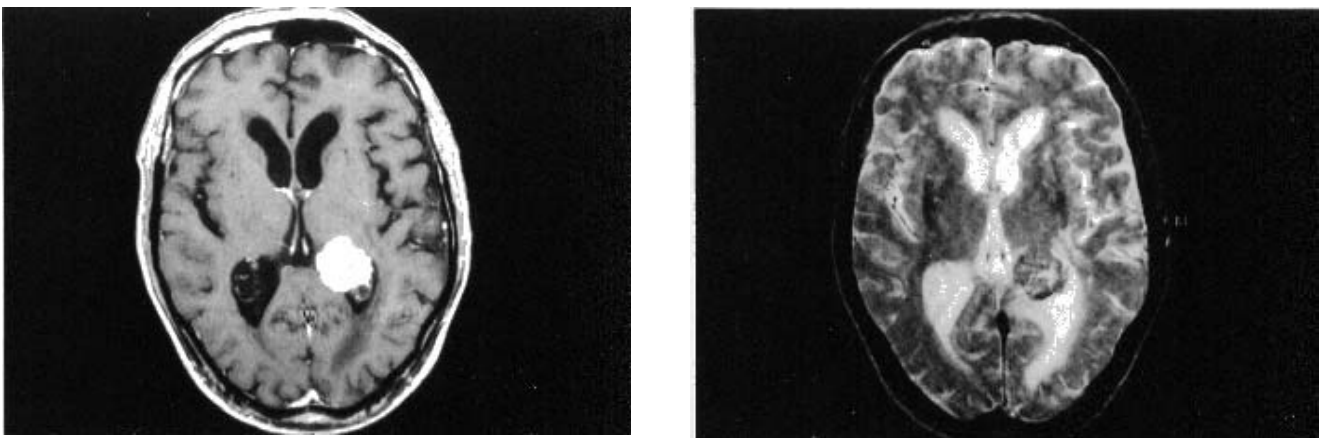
Preoperative magnetic resonance imaging. Left: T1-weighted sagittal section after gadolinium-DTPA infusion showing a solitary, solid, rounded and well-enhanced intraventricular mass 3 cm in diameter. Right: T2-weighted showing a hypo-isointense mass compared with the normal white matter with central hypointense areas.
